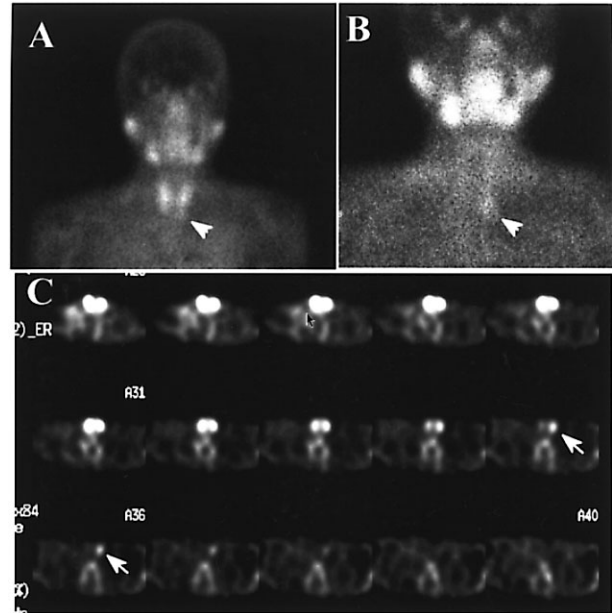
Tc-99m-MIBI parathyroid scintigrams in a patient (case No. 7) with secondary HPT due to the missed parathyroid hyperplasia. The planar image A and B were obtained 6 months after the PTX with the autograft. A delayed-phase image (B) is better in the positive delineation of abnormal gland (arrowheads) than an early-phase image (A). The early-phase SPECT image (C) shows a focus of increased uptake (arrows) just below the lower region of the left thyroid.
